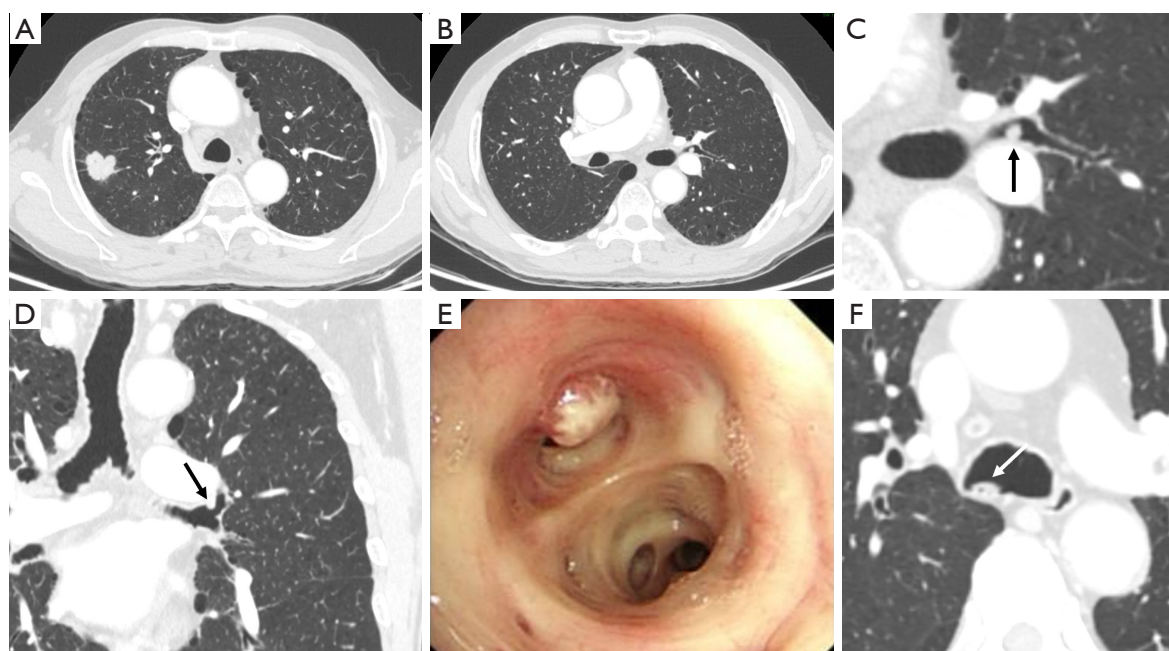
Blind spots on chest CT: trachea and bronchus. (A-E) A 65-year-old male with right upper lung lobe cancer. (B-D) Radiologists reported the main lesion in the right lung, but a small nodule in the bronchus of the left upper lobe was overlooked on CT scan (arrows). (E) Bronchoscopy revealed the neoplasm obstructing the lumen of the left upper lung lobe bronchus, which was pathologically confirmed to be a squamous cell carcinoma. (F) The trachea or bronchus tumor should be distinguished from intraluminal secretion which is more common seen as shown in this case (arrow). CT, computed tomography.
